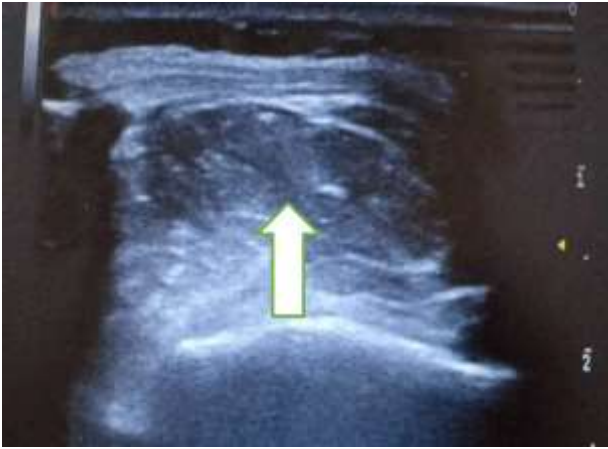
Knee Longitudinal ultrasound scan showing a well-defined and relatively hypoechoic mass lodged at Hoffa's fat pad (arrow).
